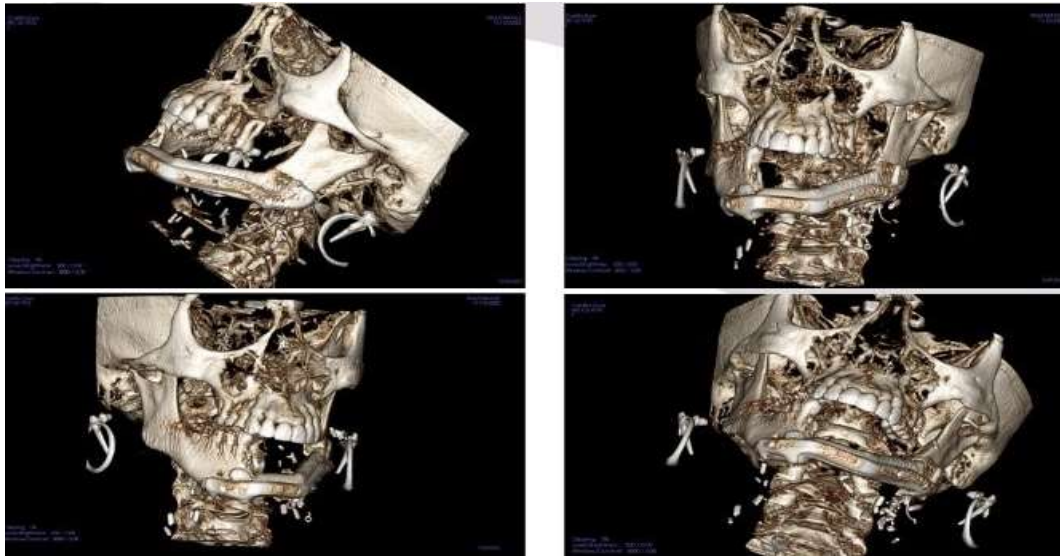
Five months follow CT showing fusion of the fibula flap with the mandibular bone
